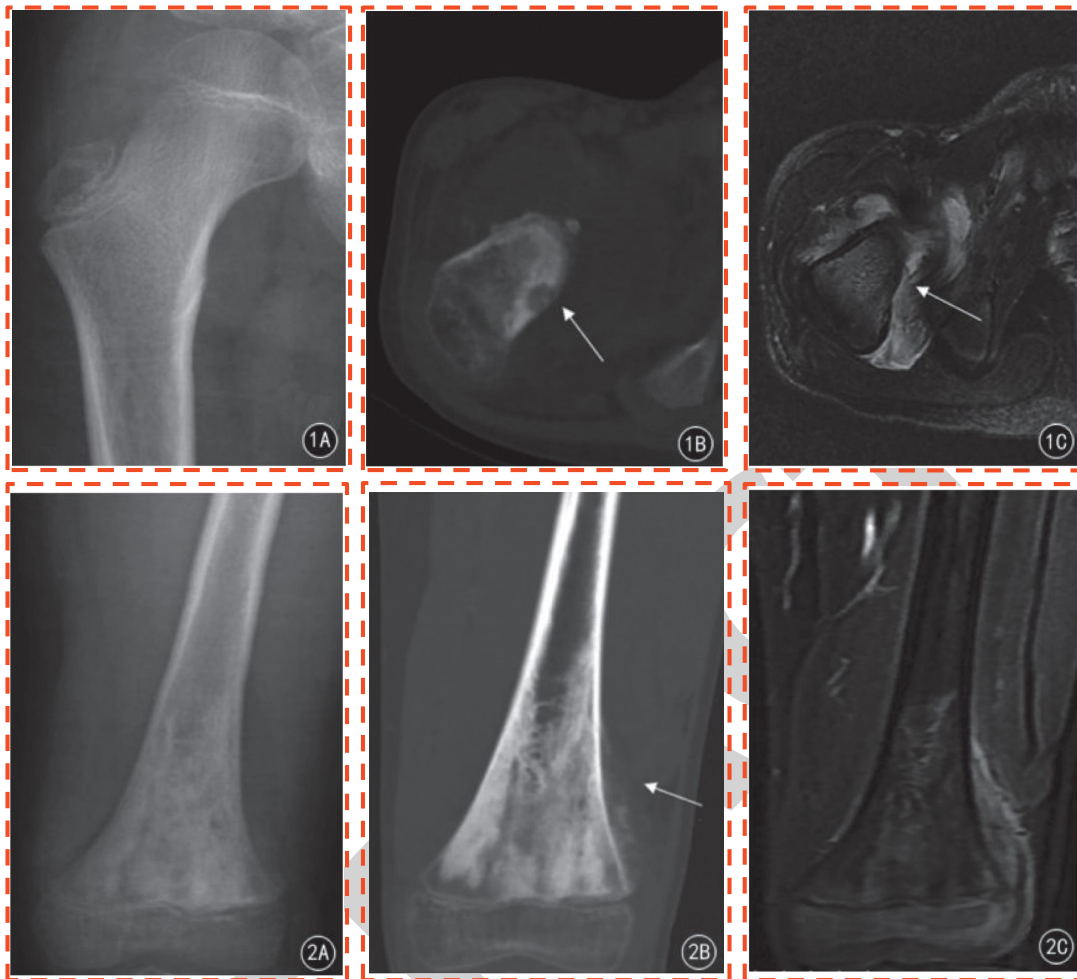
Male, 8 years old, X-ray of osteoid osteoma of the right femoral neck.
